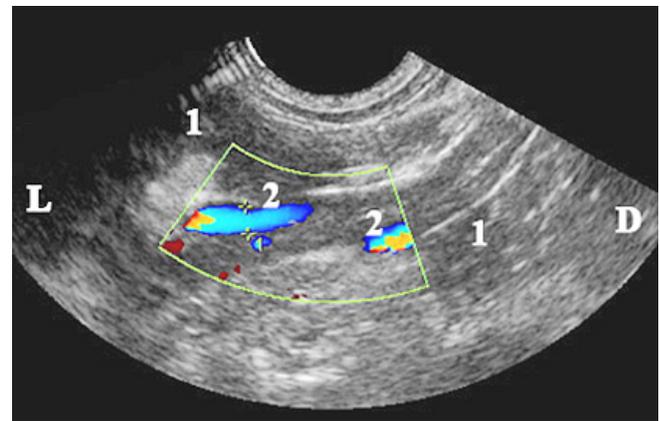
Color Doppler anatomical image of hepatic veins (color and pulse Doppler transducer – 7.5 MHz). L – left; D – right. (1) liver parenchyma; (2) hepatic veins
